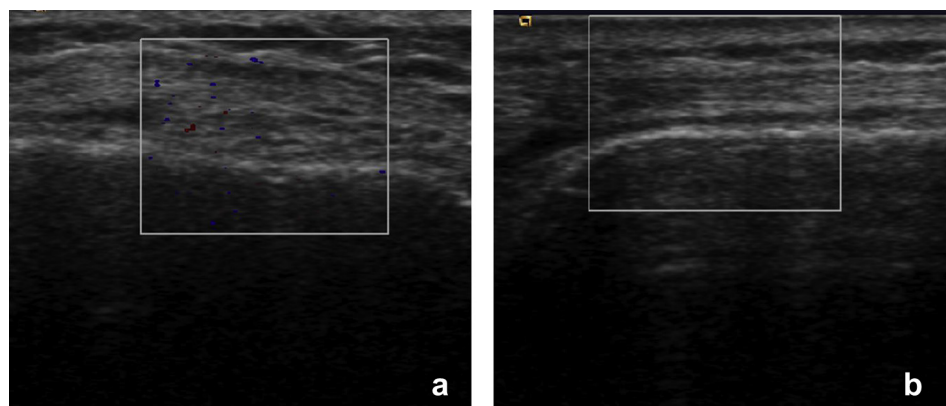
a. Colour Doppler signals of the lateral retinaculum of the affected knee of one of the patients with the knee in 10° flexion; note the inhomogenous aspect of the lateral retinaculum. b. Absence of colour Doppler signals of the lateral retinaculum of the unaffected knee of the same patient with the knee in 10° flexion.
